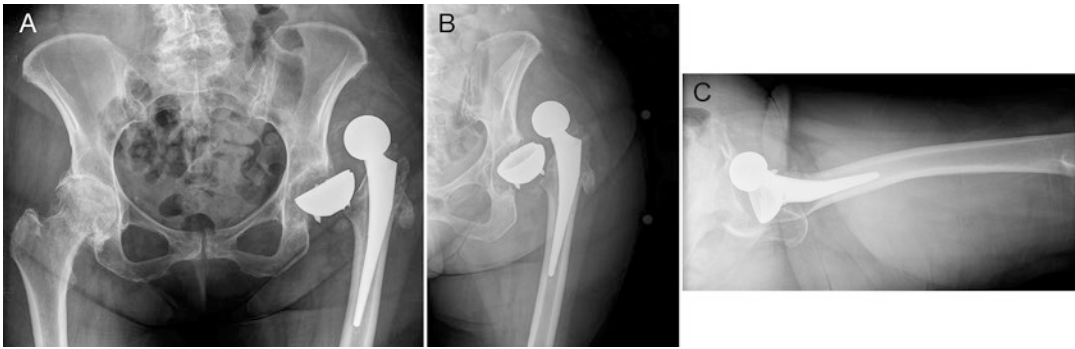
Anteroposterior (AP) view of the pelvis (a) as well as AP view of the left hip (b) and cross-table lateral X-ray of the left hip (c) demonstrate a dislocated left THA
